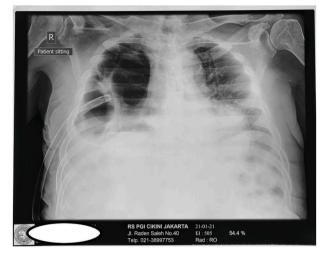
Patient chest X-ray on the 3rd day of chest tube.
